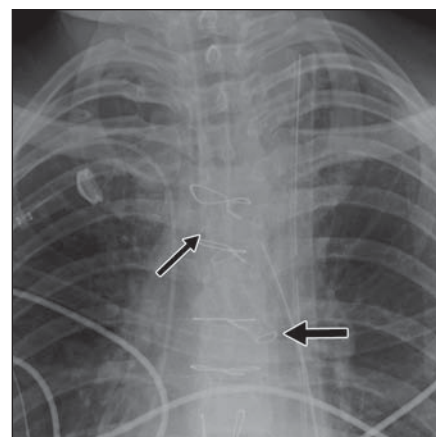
66-year-old man with left-sided double-lumen endotracheal tube. Magnified anteroposterior chest radiograph shows double-lumen endotracheal tube with its left tip (*thick arrow*) in left main bronchus. Right tip (*thin arrow*) is noted within trachea for ventilation of right lung. Double-lumen endotracheal tube allows control of distribution of ventilation to each lung. It is important to differentiate between double-lumen endotracheal tubes and inadvertent selective bronchial intubation with single-lumen catheters.
